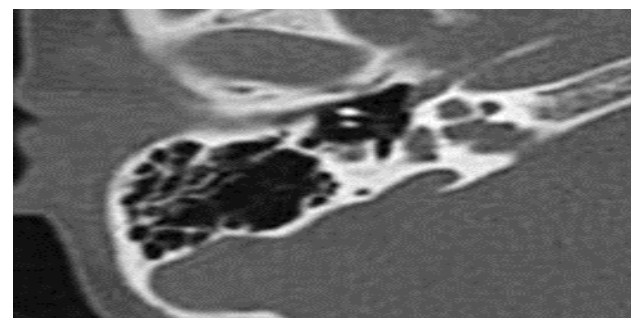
Wide vestibular aquaduct appearance in Temporal HRCT
